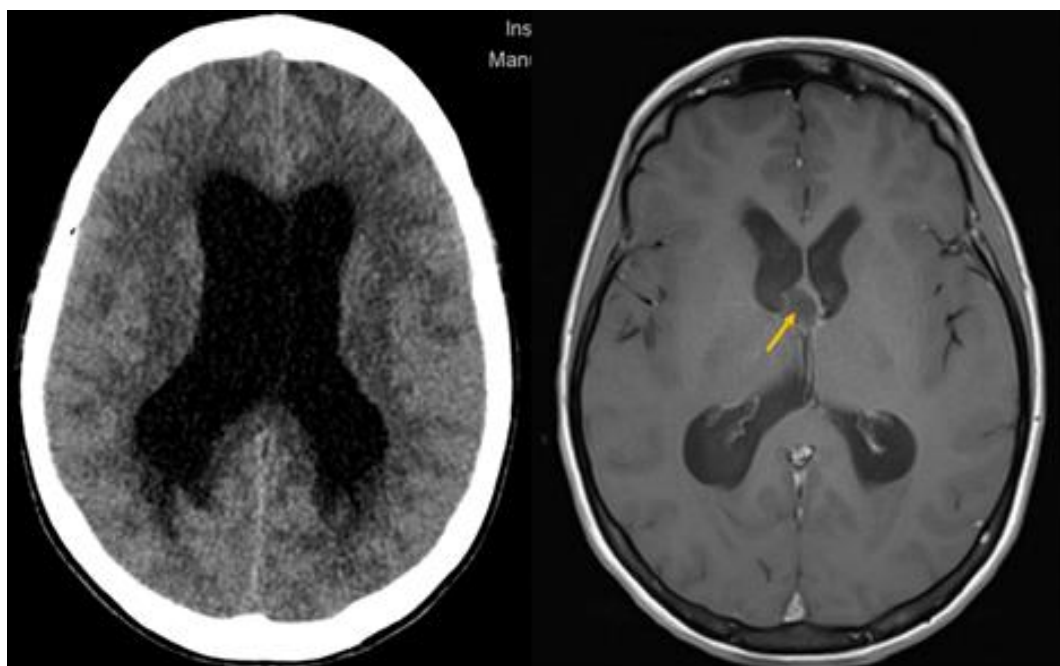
Hydrocephalus and dilation of the lateral ventricles identified in cranial computed tomography (left) and cranial magnetic resonance imaging showing a rounded obstructive lesion (yellow arrow) located in the region of the foramen of Monro, consistent with a colloid cyst (right).
